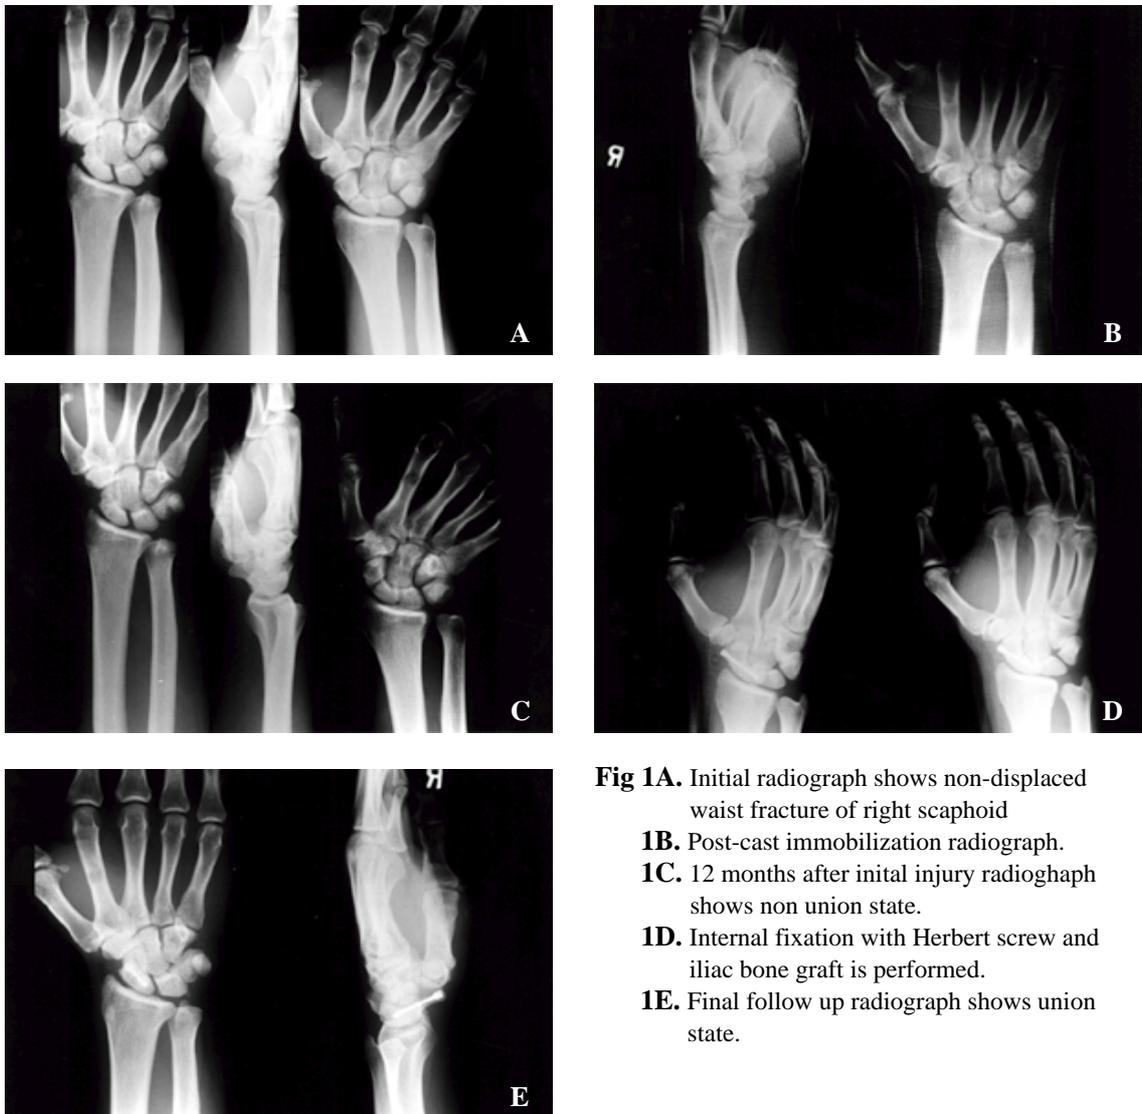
Initial radiograph shows non-displaced waist fracture of right scaphoid
